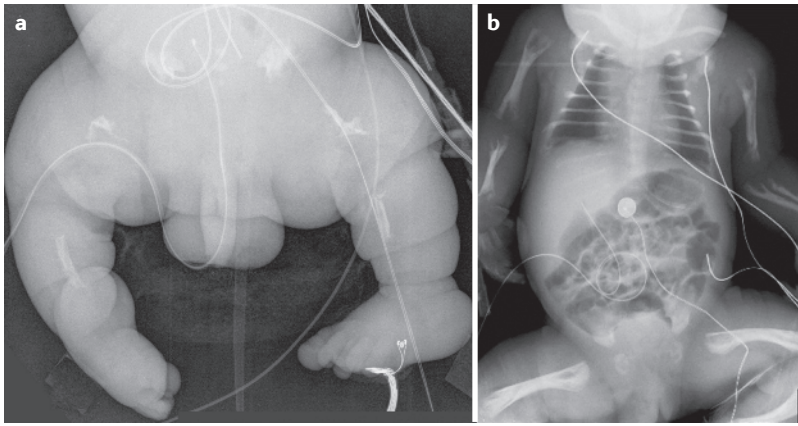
Radiographic features of perinatal hypophosphatasia. a | Skeletal mineralization is nearly absent in this neonate. Only small bony areas are apparent in the pelvis, femurs and tibias. b | Noticeable rickets is present in this neonate. Pathognomonic metaphyseal 'tongues' of radiolucency, gracile ribs and long-bone deformities are apparent.
